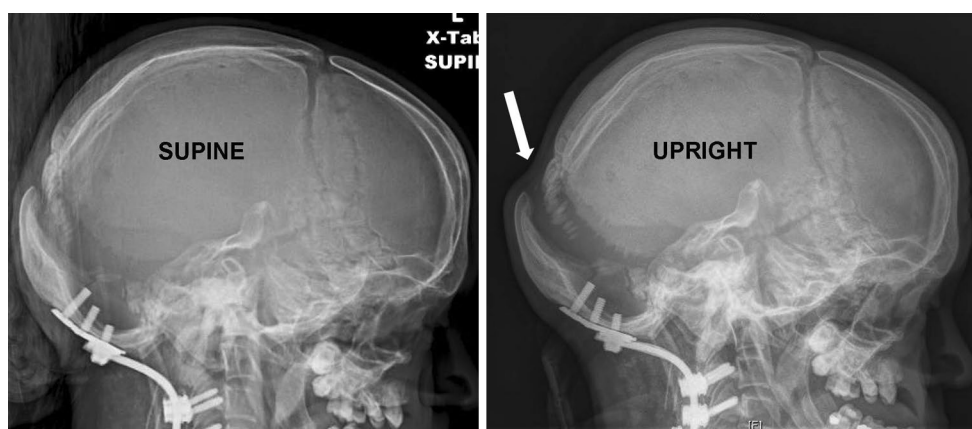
Following halo vest removal, dynamic instability is seen. Supine (left) and upright (right) radiographs demonstrate increased lambdoid suture diastasis in the upright position compared with the supine position
